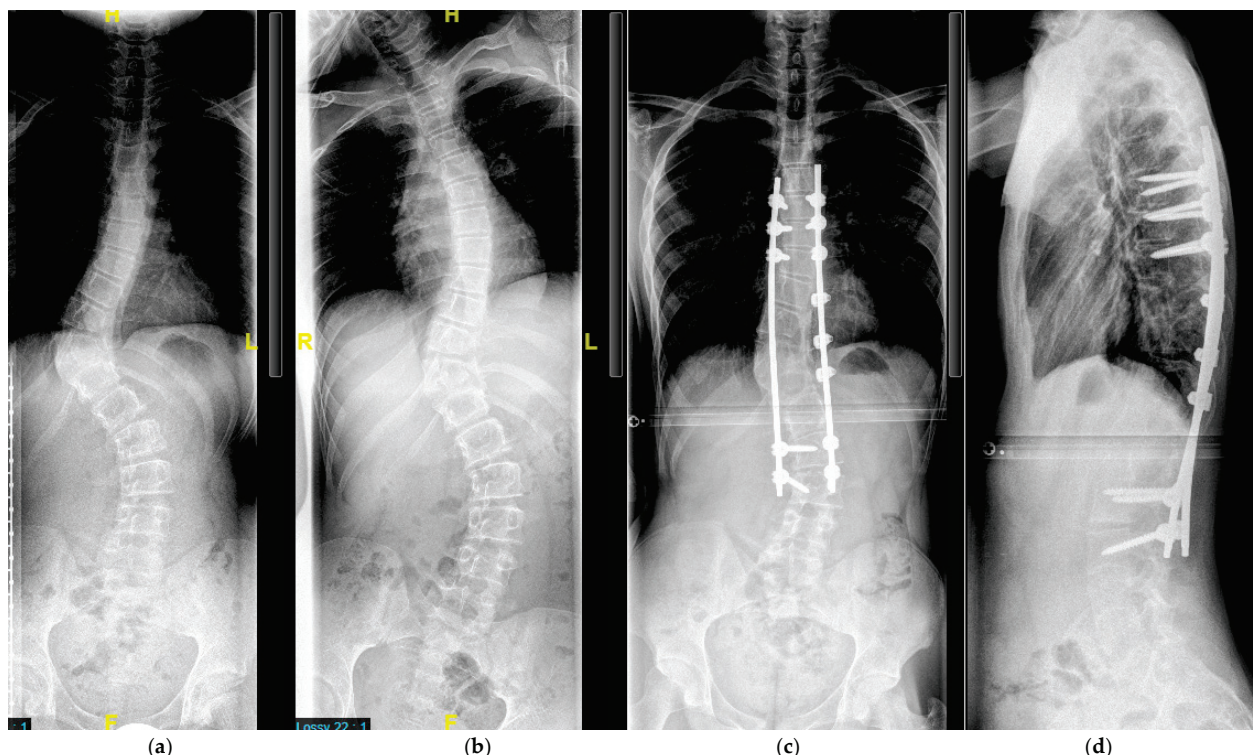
Sixteen-year-old patient with severe scoliosis of 65° Cobb (a). Good curve flexibility on the lateral bending film (b). AP (c) and lateral (d) radiographs after posterior-only spinal fusion T7–L3. Fixation in the upper thoracic and the lumbar spine with transpedicular screws, fixation in the apical dystrophic area with sublaminar wires.
